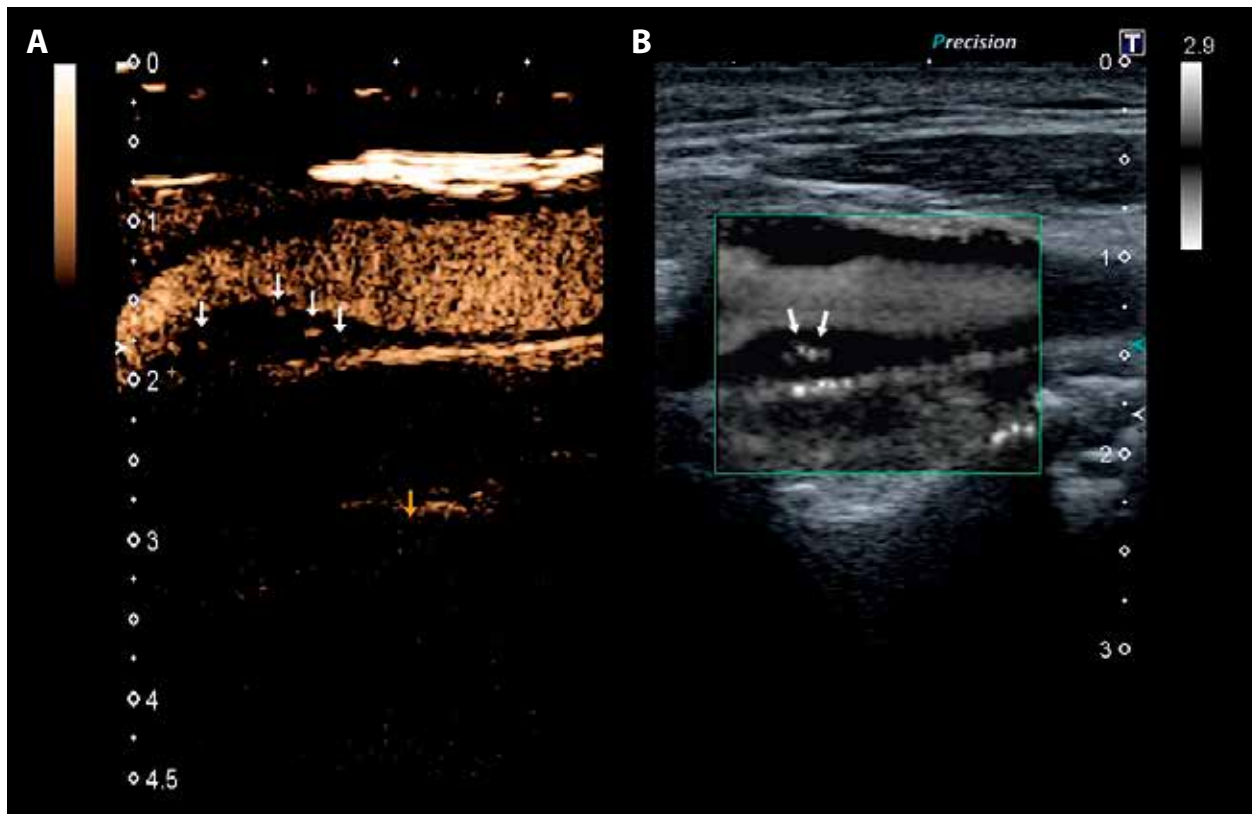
Contrast-enhanced ultrasound (CEUS) (A) and Superb Micro-vascular Imaging (SMI) (B). More than 70% carotid stenosis, predominantly hypoechoic plaque located at the far wall of the right internal carotid artery in an asymptomatic patient. (A, left) CEUS examination of the plaque. Contrast material influx is yellow in color, arrow points at contrast microbubble enhancement moving toward the plaque core and lumen, Grade 3. (B, right) SMI examination of the plaque. The SMI region of interest is positioned to show the entire plaque, arrow points at intraplaque microvascular flow (IMVF) signals moving towards the plaque core and lumen, Grade 3.
